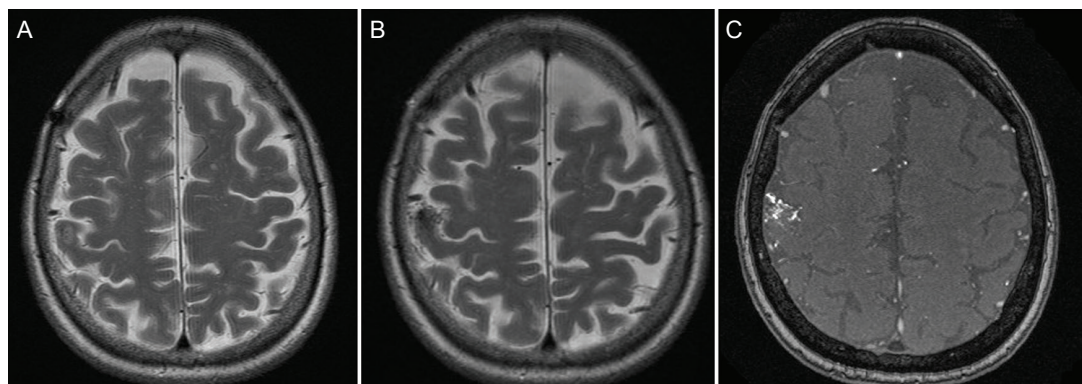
Postoperative magnetic resonance imaging (MRI). A: T2-weighted axial section MR image three years after craniotomy; B: Five years after craniotomy, spotty lesions with low intensity appeared in the right post-central gyrus; C: Time-of-flight sequence MRI axial section detected a newly developed lesion with high-flow vasculature in the right post-central gyrus, indicating de novo arteriovenous malformation.
